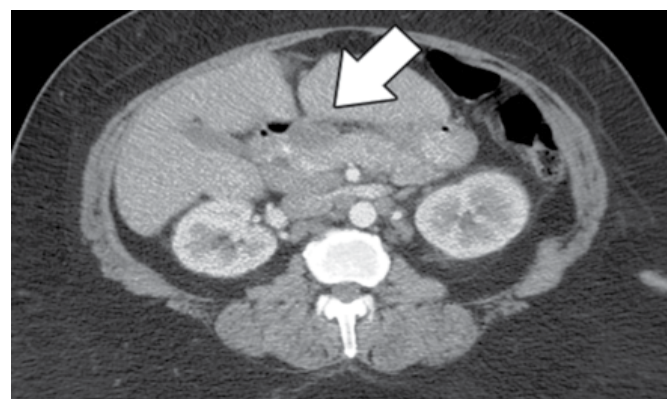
Computer tomography (CT) scan findings in a patient with pancreatic sarcoidosis.
